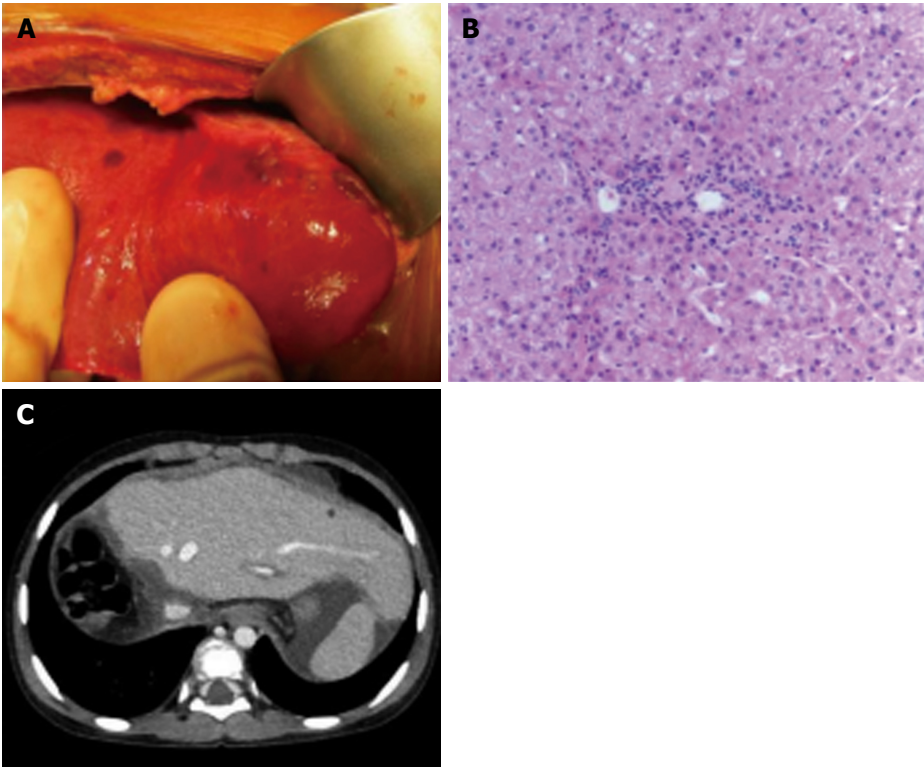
Clinical findings during the recipient's surgery. During living donor liver transplantation, we identified the small lesions of the graft liver suspected as biliary hamartoma after reperfusion (A). Time zero biopsy of the graft liver revealed slight fibrosis around the portal area; metavir fibrosis score F0 (B) (magnification $\times 100$). Computed tomography scan on postoperative day 28 (C).
